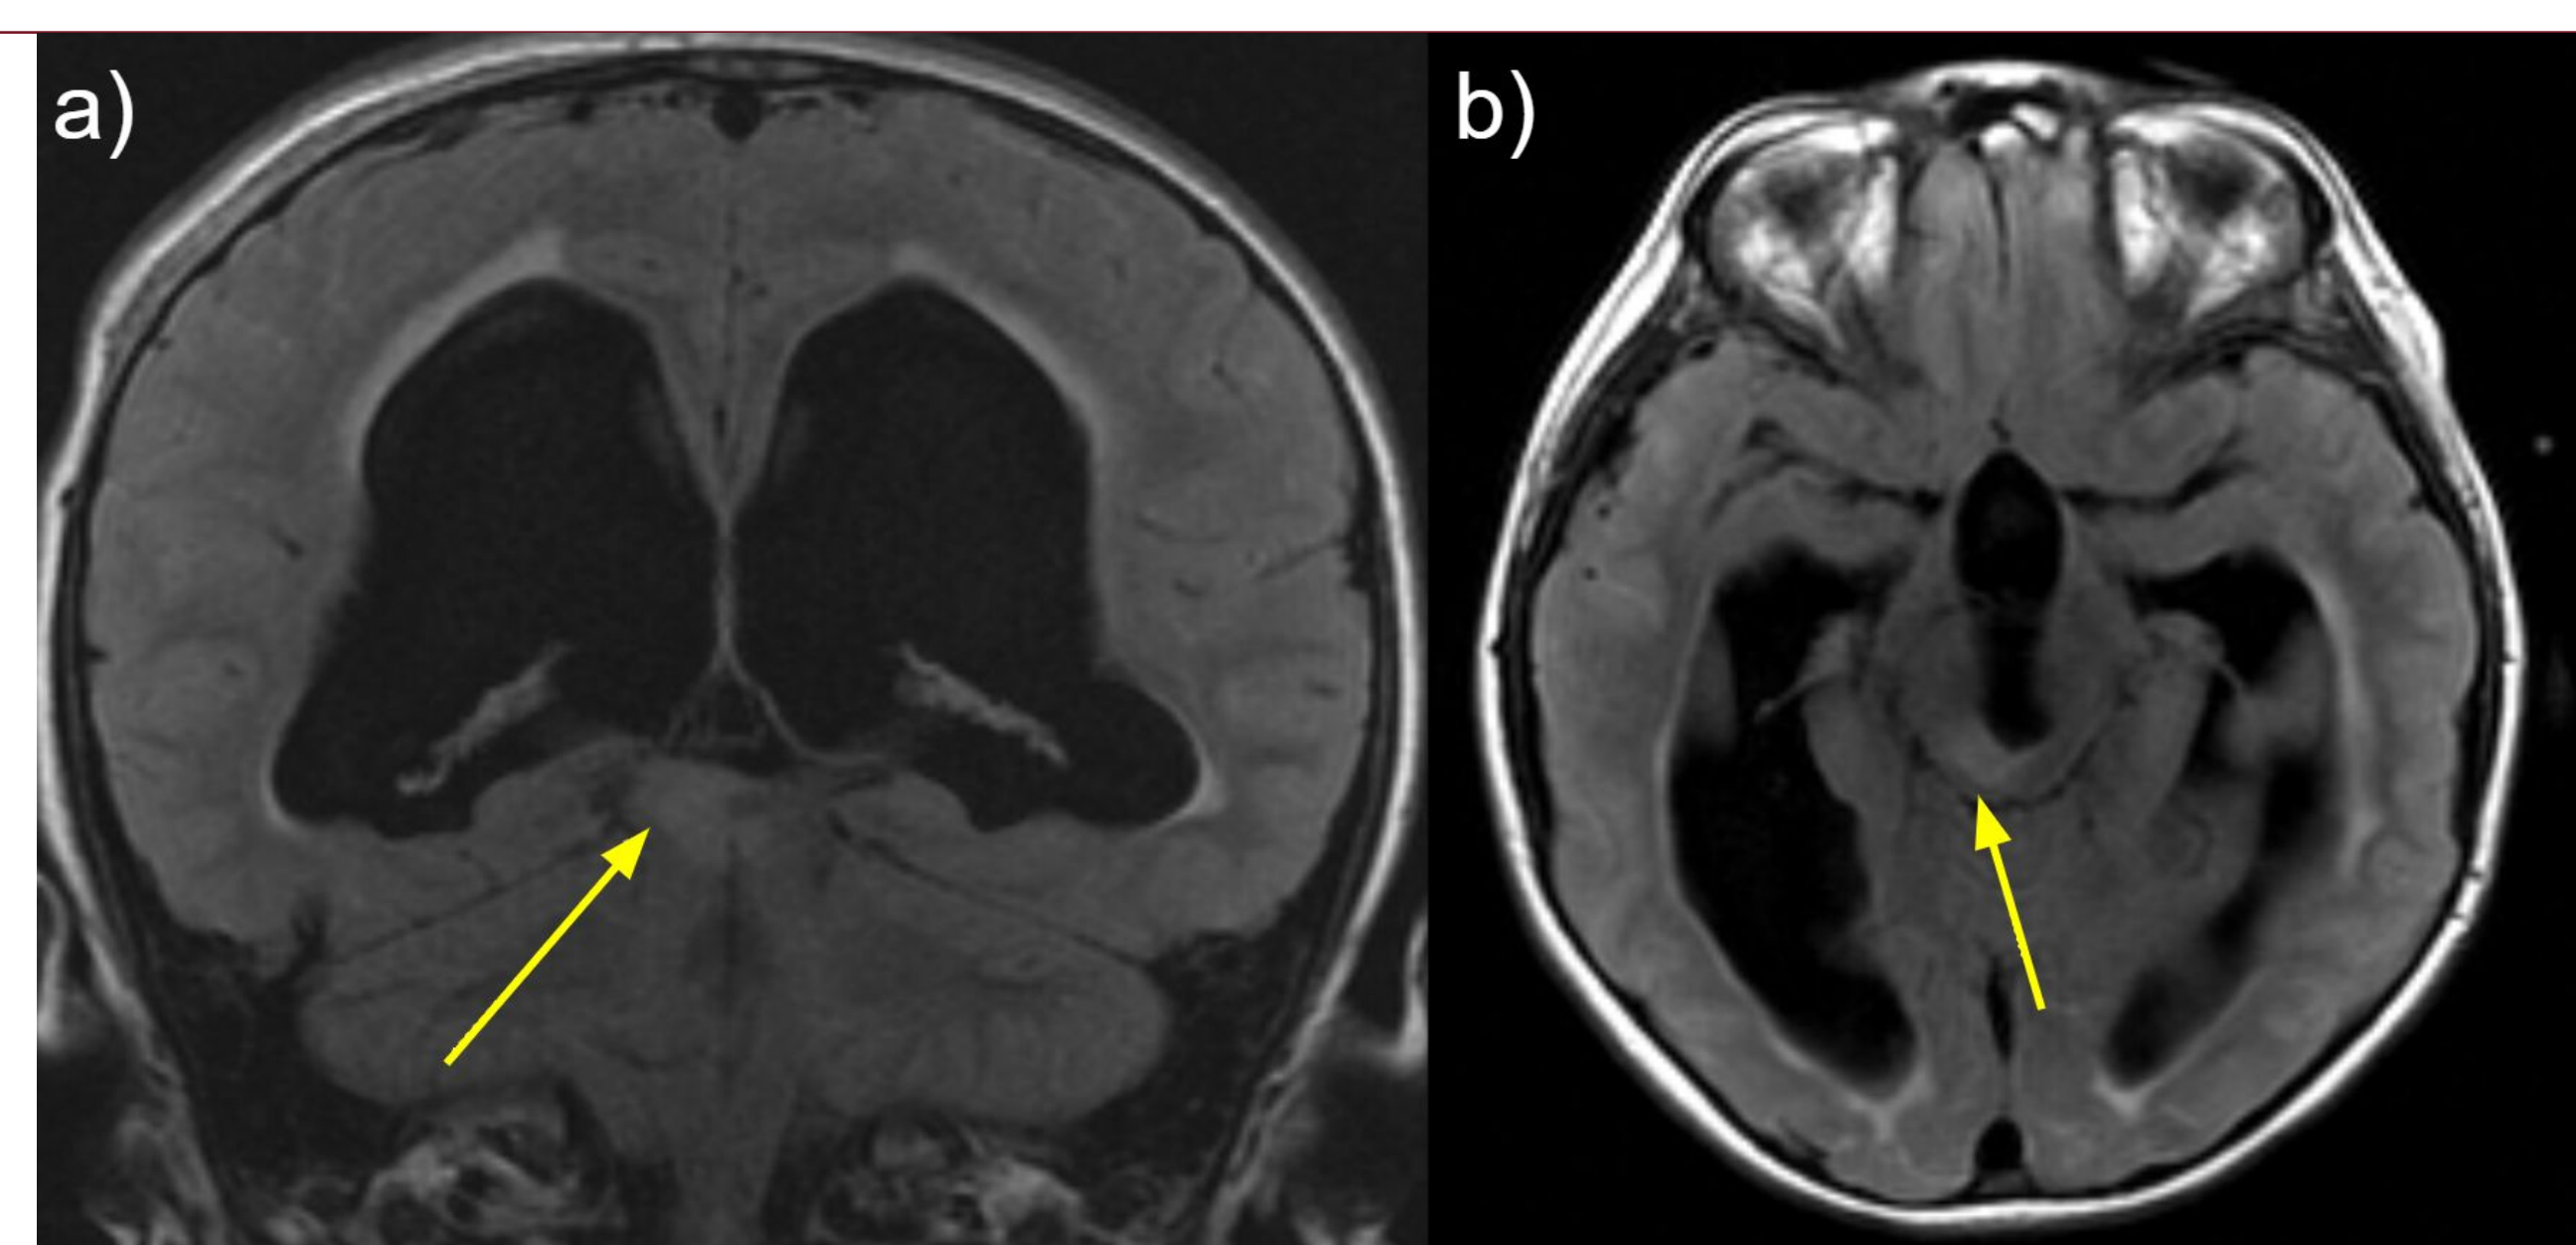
T2-weighted MRI FLAIR image in the (a) coronal and (b) axial planes demonstrating a hyperintense tectal lesion concerning for low grade glioma.
